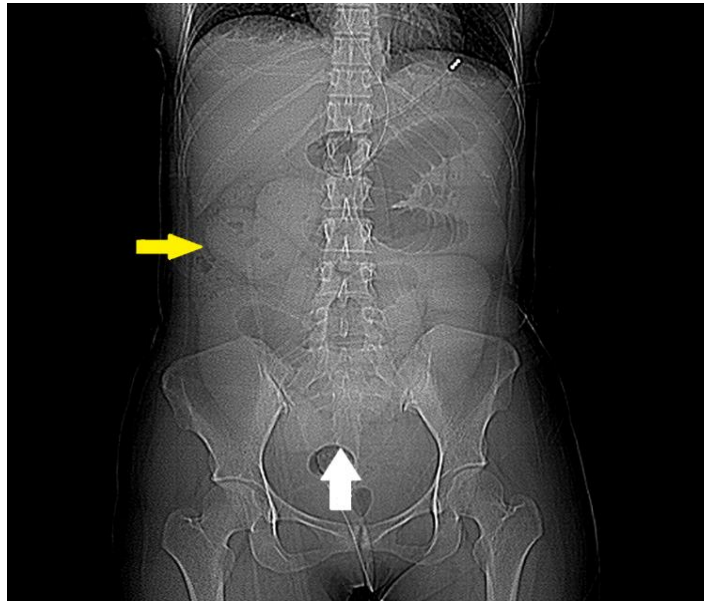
Supine abdominal radiograph demonstrating dilated loops of proximal small bowel in the central part of abdomen, (yellow arrow), containing non-ionic oral contrast, consistent with small bowel obstruction. A transition point is noted in the mid pelvis position (white arrow), suggestive of a mechanical etiology.
